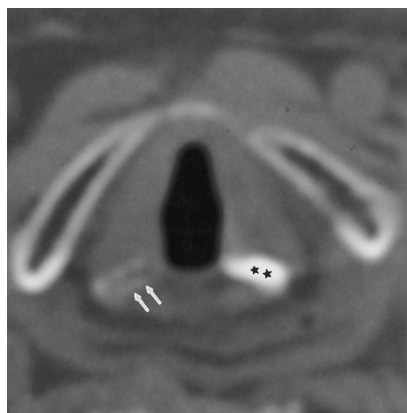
CT scan in a 72-year-old woman with a history of pemphigus with involvement of the face, pharynx, and eye, but normal false and true vocal cord function at the time of this study. Note significant sclerosis of the body of the arytenoid cartilage on the left side (*stars*). The body of the right arytenoid cartilage (*arrows*) is normal in appearance.
